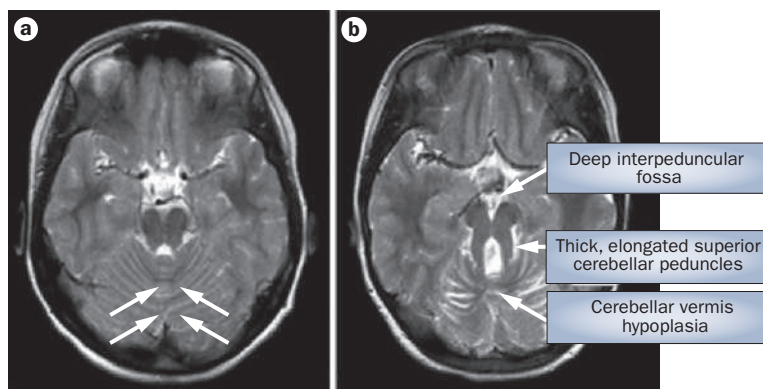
The ‘molar tooth sign’ associated with Joubert syndrome. a | An axial MRI image through the cerebellum and brainstem of a healthy person shows the intact cerebellar vermis (white arrows). b | An axial MRI image through the cerebellum and brainstem of a child with Joubert syndrome shows the three components of the molar tooth sign. Parisi, M. & Glass, I. (Updated March 8, 2007). Joubert Syndrome. In *GeneReviews at GeneTests: Medical Genetics Information Resource* (database online). © University of Washington, Seattle. 1997–2009. Available at <http://www.genetests.org>. Accessed June 22, 2009.
